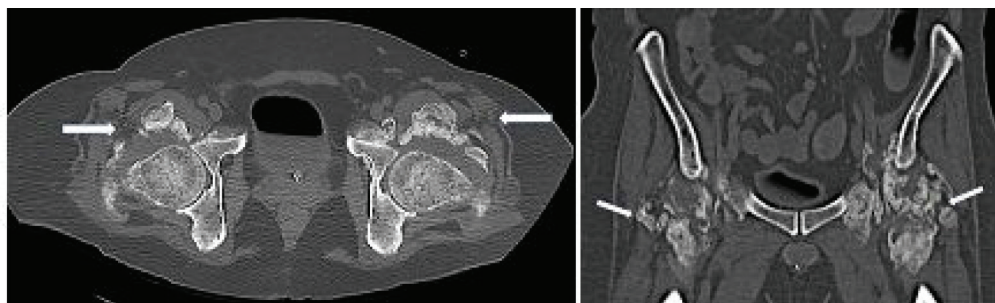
Under computed tomography guidance, corticosteroid injection was made to the periarticular portions of both hips (shown by arrows).
